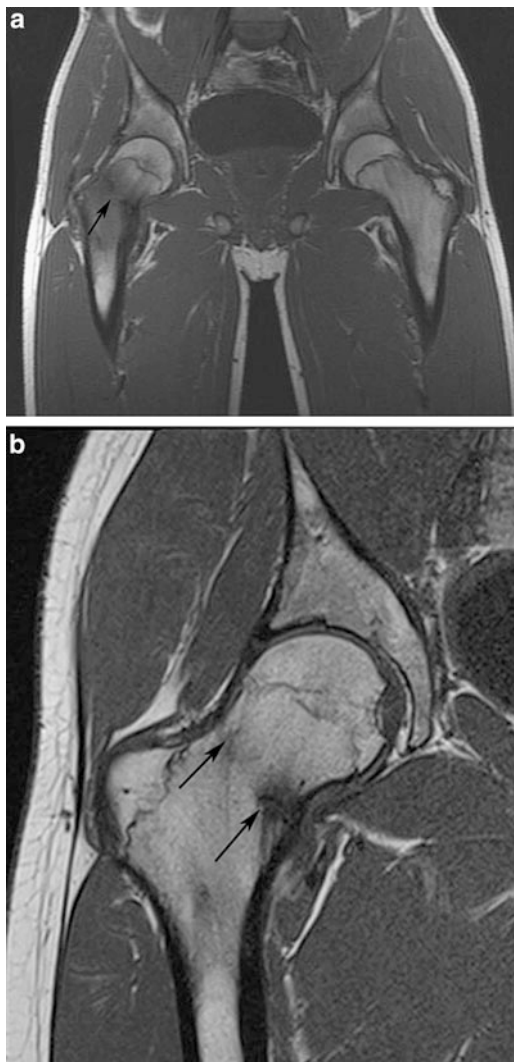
Coronal T1-weighted images through the right hip in a 15-year-old male with femoral neck fracture. (a) Initial images performed with a large FOV through both hips using a body matrix coil demonstrate the fracture line (*black arrow*), but with poor spatial resolution. (b) A follow-up scan performed with a surface coil demonstrates the healing fracture (*black arrows*) with significantly improved spatial resolution. Both studies were performed on a 1.5 T magnet
